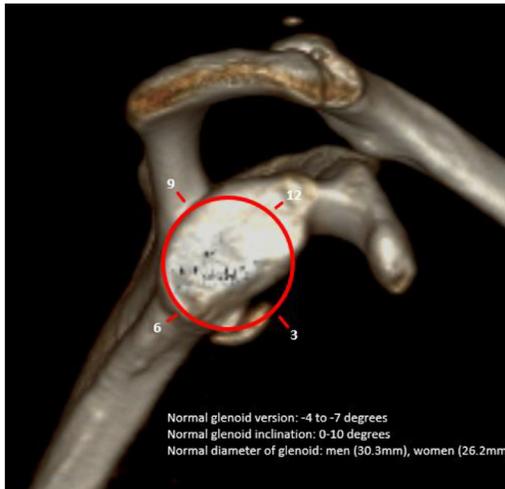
Three-dimensional CT reconstruction of the glenoid and scapula demonstrating the clock-face orientation used for describing glenoid morphology.
